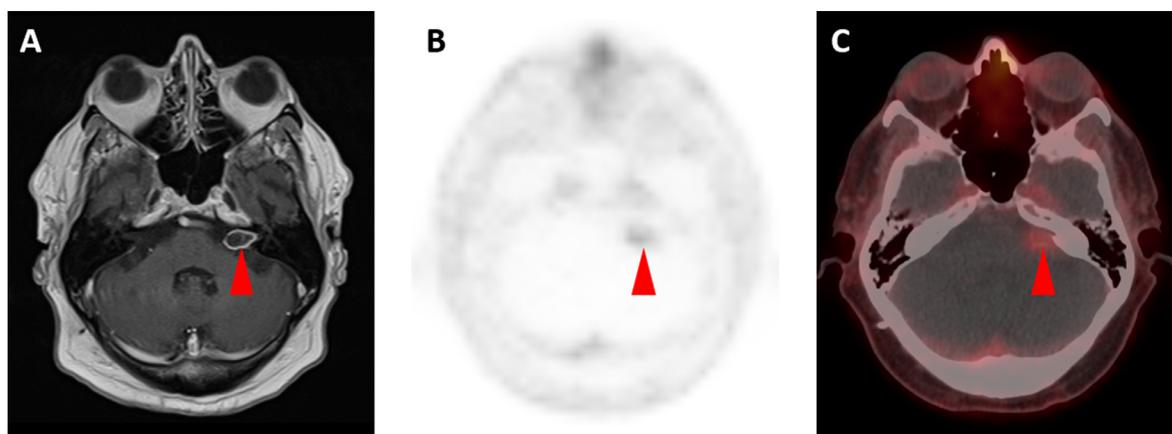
(A) Axial, T1, postcontrast magnetic resonance image of the brain of an 80-year-old man demonstrating a peripherally enhancing, centrally cystic lesion at the left cerebellopontine angle (red arrowhead), consistent with a vestibular schwannoma. This lesion demonstrates PSMA-targeted radiotracer uptake on (B) axial ^{18}F -DCFPyL PET and (C) axial ^{18}F -DCFPyL PET/CT images through the brain (red arrowheads).
